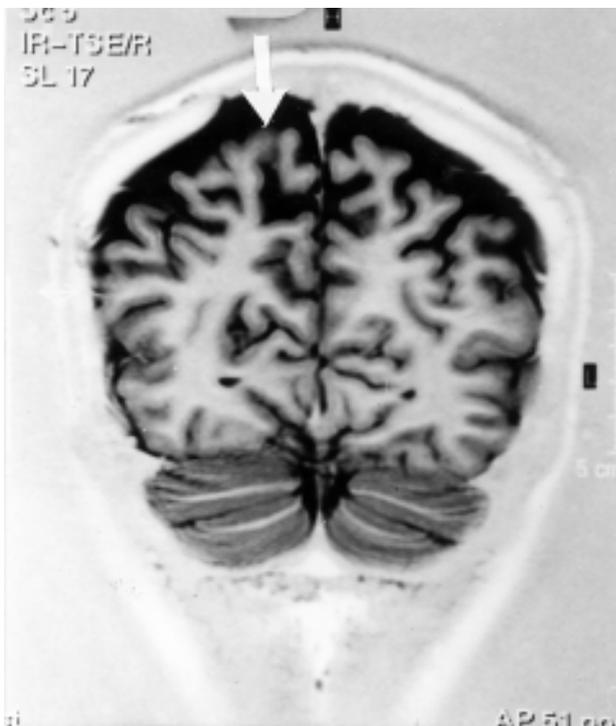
Cortical atrophy (arrow) in MRI (T1 weighted image, coronal plane) in a 30-year-old patient with Crohn's disease and amnesia.
